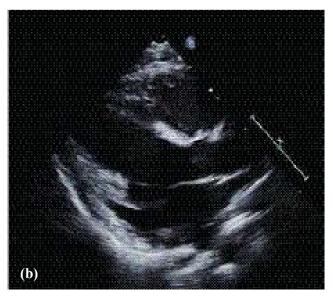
a. Four chamber echocardiogram showing a dilated left ventricle, demonstrating bright echoes in a dyskinetic septum, indicating the presence of scar tissue. LV, Left ventricle; LA, left atrium. Bright area indicated by "scar" with arrows. b. Echocardiogram (parasternal long axis view at end-diastole), demonstrated a hyperechoic basal and mid-ventricular septum, papillary muscle, and posterior left ventricular (LV) wall
